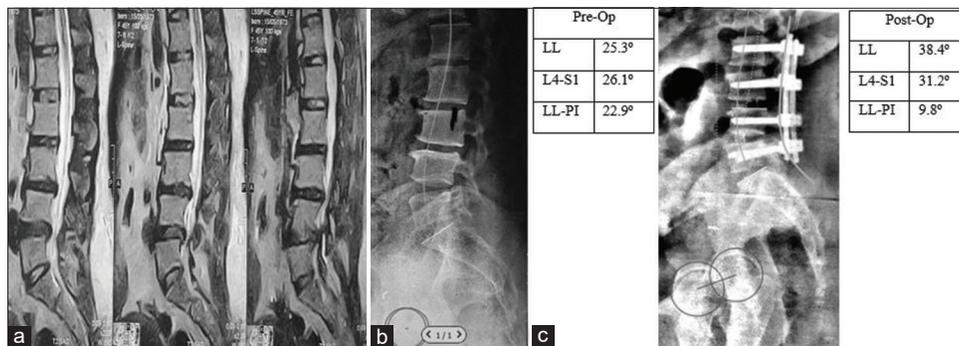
Showing preoperative and postoperative imaging and radiological measurements. (a) Preoperative lumbosacral sagittal MRI, (b) preoperative lumbosacral lateral X-ray, and (c) postoperative lumbosacral lateral X-ray.
